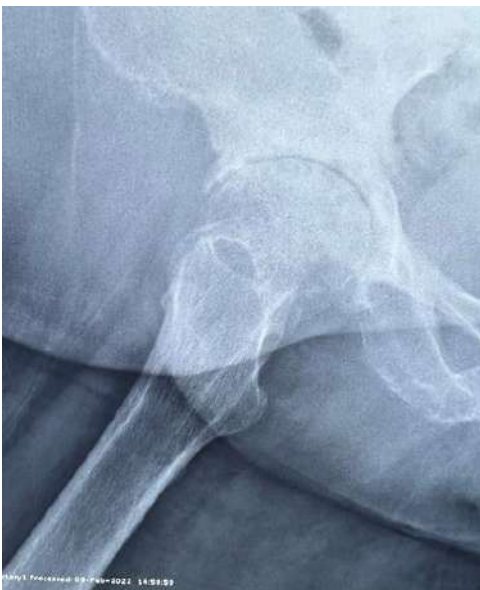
X-ray of right hip joint 14 months post procedure (February 2022)
